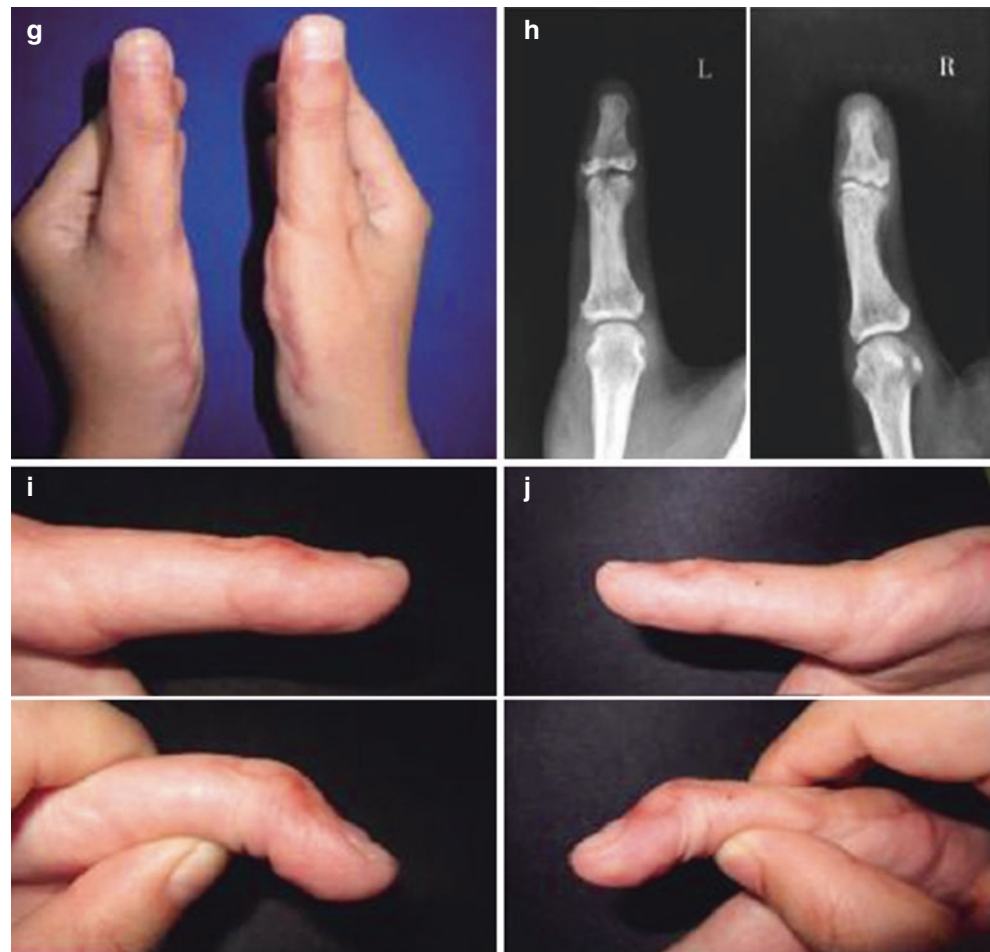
Open wedge osteotomy treatment for bilateral deformities of thumb deviation. (a) Preoperative hand appearance. (b) X-ray indicates the presence of delta phalange. (c, d) Perform the sawtooth-shaped incision at the convex side, retain the normal interphalangeal articular surface, and perform wedge osteotomy to resect the delta phalange and phalange articular surface. (e, f) Postoperative use of Kirschner silk for fixation. (g) Hand appearance at 4 months after operation. (h) X-ray indicates that the delta phalangeal and distal phalangeal articular surfaces have been fused. (i, j) The bilateral thumb interphalangeal joints have good flexion and extension functions.
